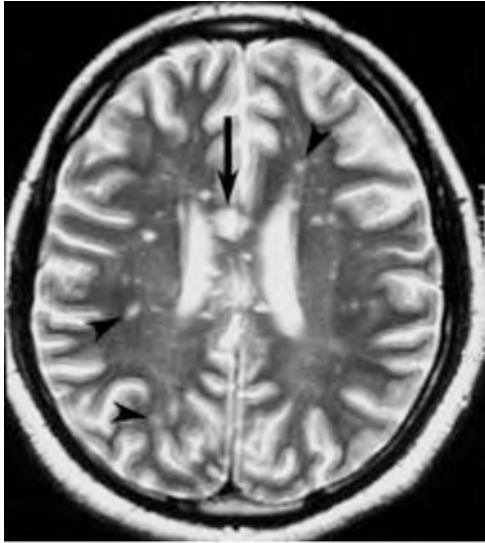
MRI T2 weighted image showing multiple small high signal intensity lesions in periventricular white matter and corpus callosum.
